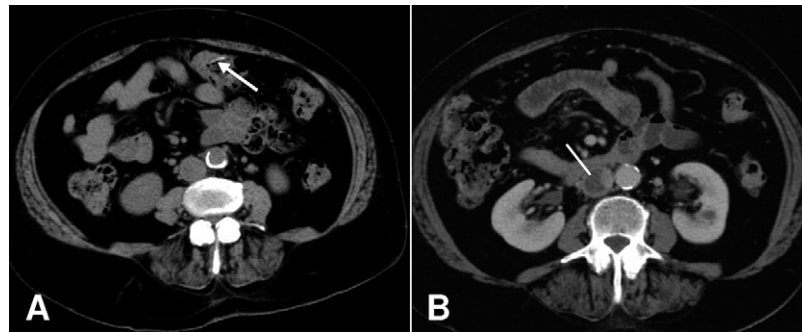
A, cross-sectional CT scan showing the apparently migrated fish bone inside transverse colon (*white arrow*). B, cross-sectional CT scan demonstrating partial thrombosis of the IVC (*white line*).
